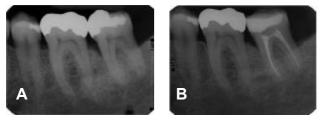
X-ray of the defect tooth 18, 19: A - at baseline; B - treated with PPT and enamel matrix proteins 3 years after.
